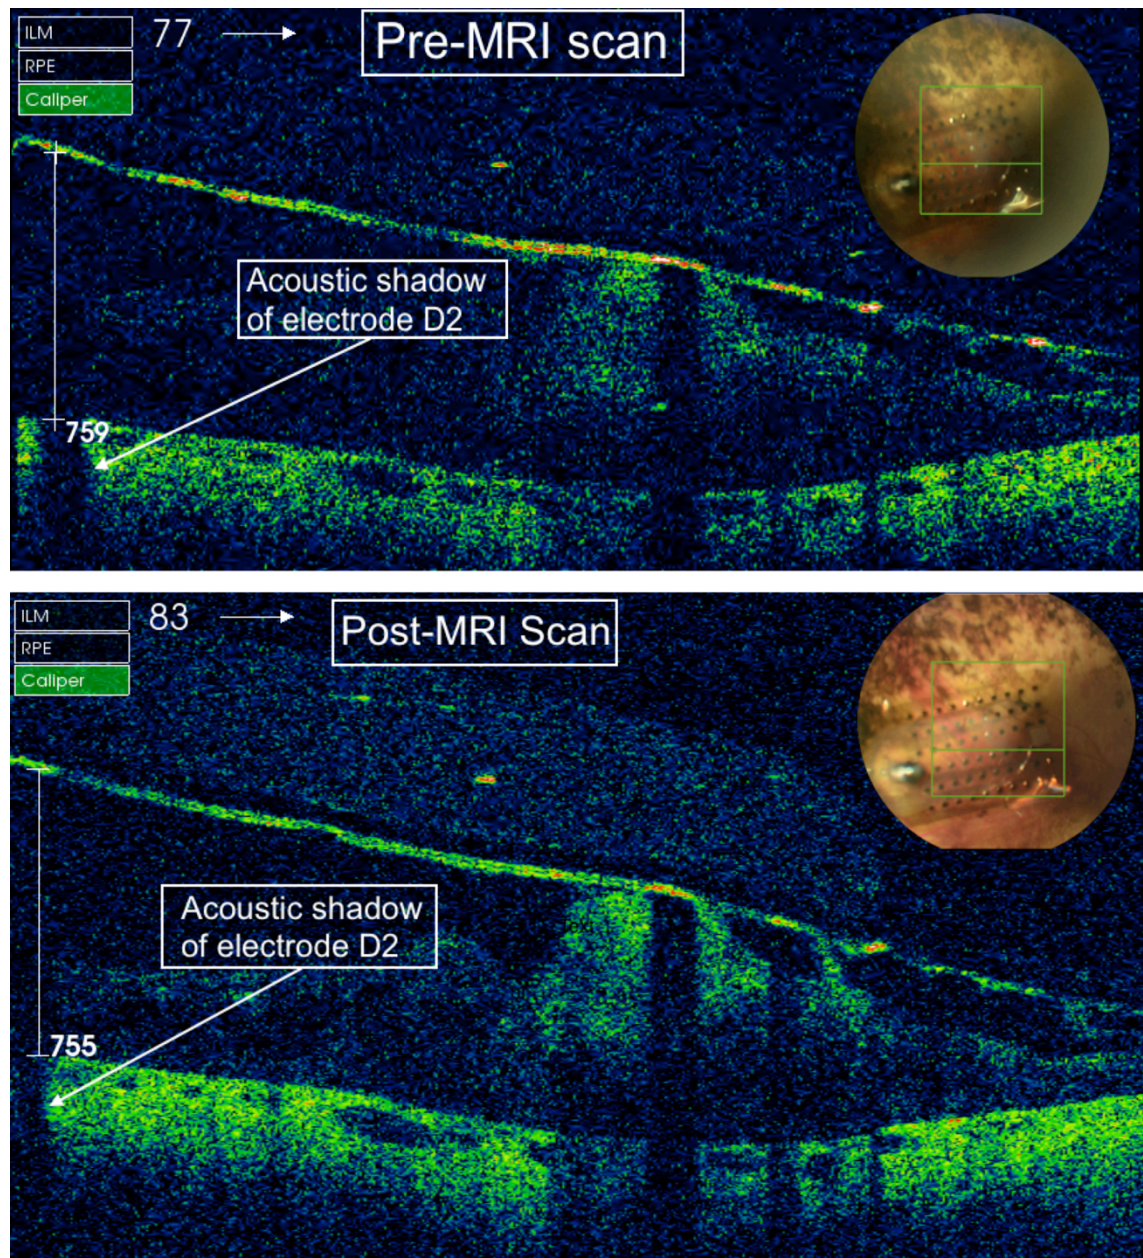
OCT image (Topcon 3D-OCT 2000) of Argus® II implant in the right eye of subject 51-001 at 6 months before the MRI brain scan (top image), and at 1 months after the scan (bottom image). In the pre-MRI OCT, the under surface of the retinal implant at electrode position D2 (second electrode of third row) was separated from the retinal surface by 759 microns. In the post-MRI OCT, the distance of retinal implant separation from the retinal surface under the electrode remained similar at 755 microns, indicating minimal change in axial position in relation to retinal surface. (Image from (Luo et al., 2013))
